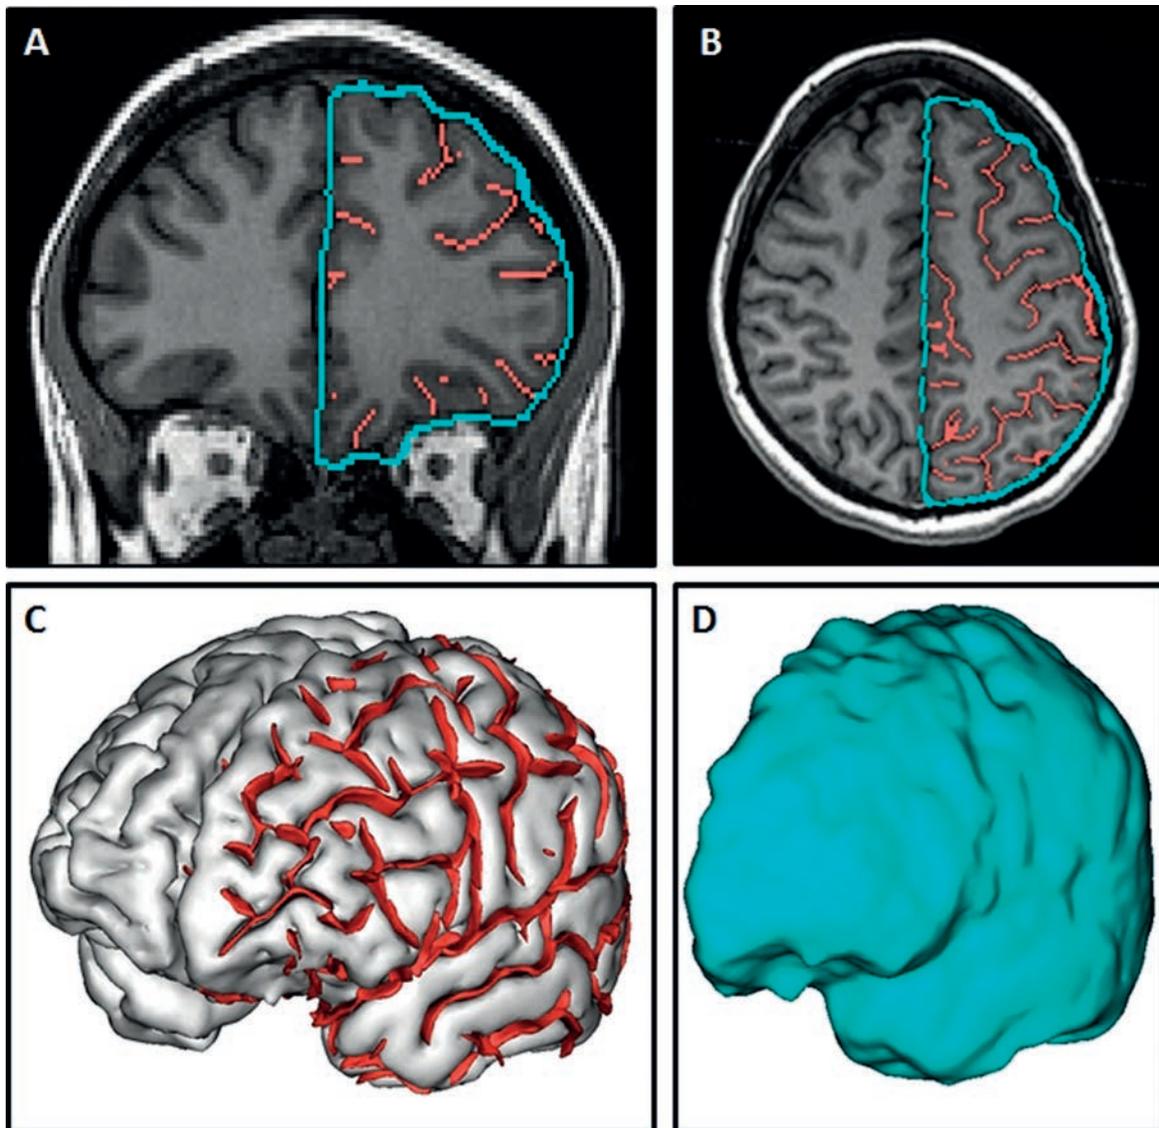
Three-dimensional segmentation of the cortical folds and global sulcal index (g-SI). Automatically segmented cortical folds (A, B, C; in red) and smooth envelope of the brain mask (A, B, D; in blue) represented on two-dimensional magnetic resonance imaging slices (A: coronal, B: axial) and using mesh-based three-dimensional reconstruction (C: cortical sulci and brain surface, D: brain hull surface).
